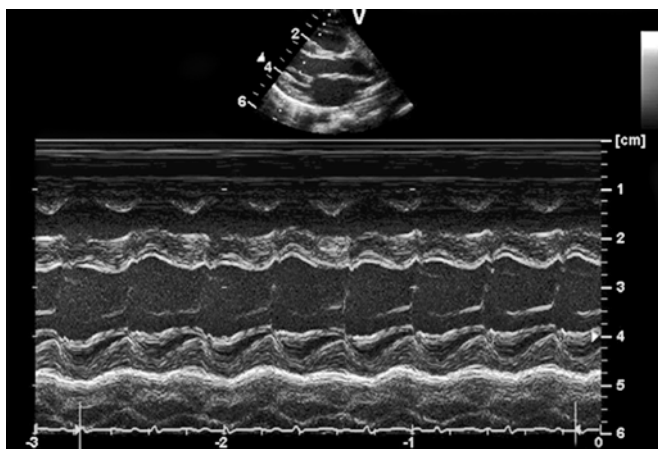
Normal M mode echocardiogram through left ventricle
